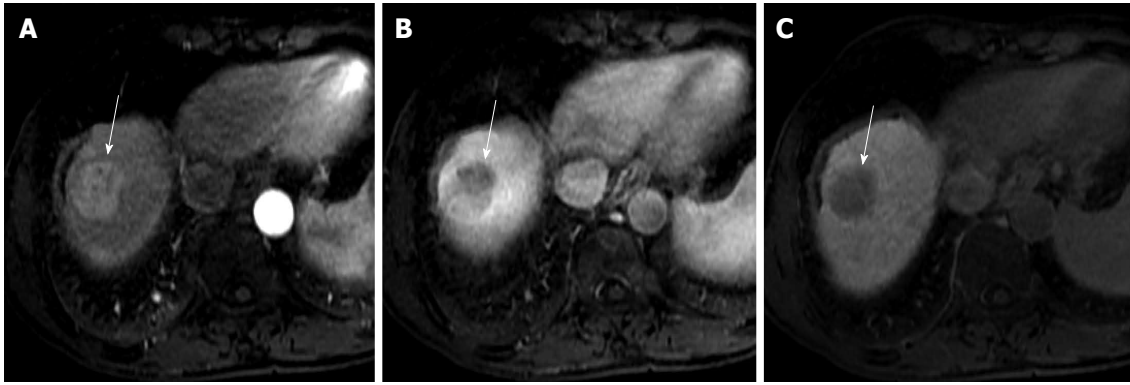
Imaging features of a typical hepatocellular carcinoma. Axial magnetic resonance images show a hypervascular lesion in the arterial phase (A, white arrow), located in the top of the liver, with wash-out clearly in the portal venous phase (B, white arrow). This enhancement pattern represents the typical morphological hallmark of hepatocellular carcinoma. The nodule has an increased arteriolar supply and reduced portal vascularization. In hepatobiliary phase, the lesion appears hypointense to the surrounding liver parenchyma.
